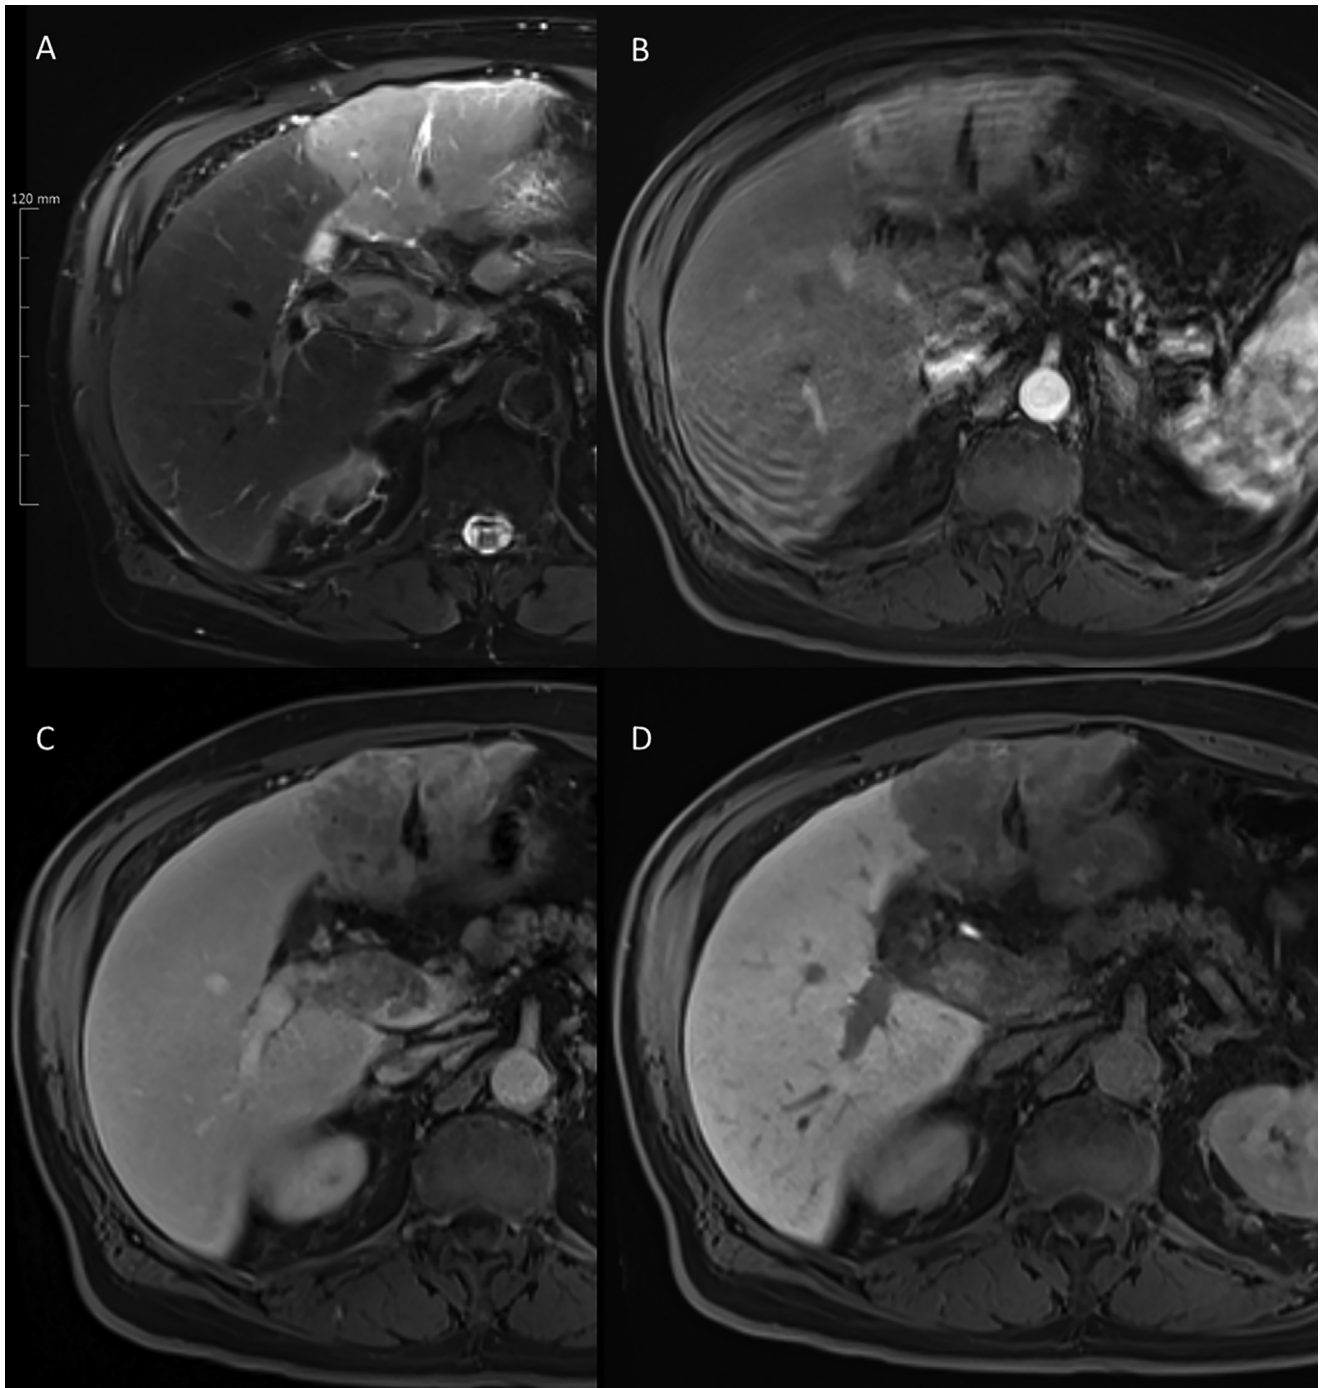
MRI showed a T2 hyperintense left lobe (A) with early enhancement on arterial phase (B). Washout of the altered left liver lobe can be appreciated on portal venous and venous phase (C). The left liver lobe showed no hepatocyte uptake during the hepatobiliary phase (D).
